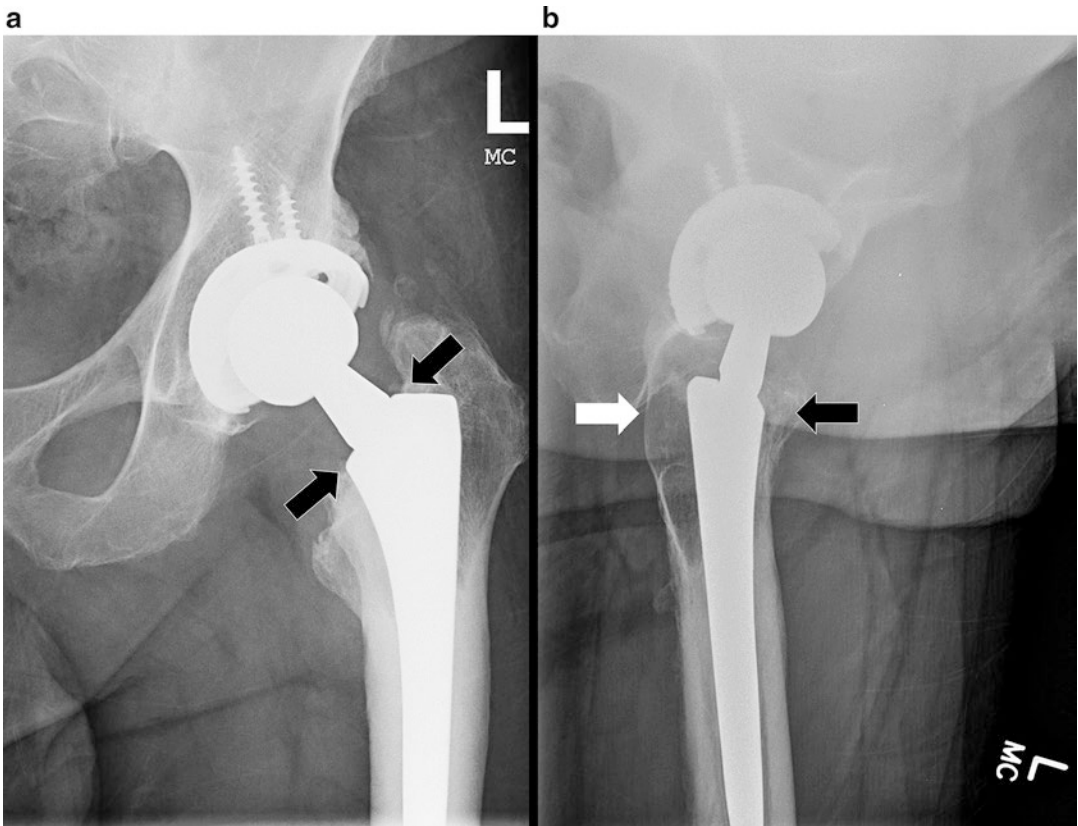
Anteroposterior (a) and lateral (b) radiographs of a patient with recalled dual-modular femoral neck-stem with trochanteric osteolysis (*white arrow*) juxtaposed to neck-stem modularity junction (*black arrow*)
